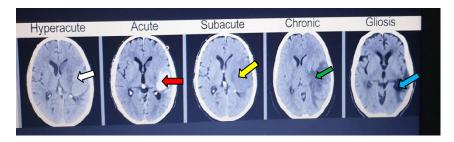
Changes in the appearance of hemorrhagic stroke on computed tomography. (A) Hyperacute = fresh blood, (B) acute = clotted blood, (C) subacute = starting of HG breakdown, (D) chronic = complete HG breakdown and (E) gliosis = necrosis and atrophy
